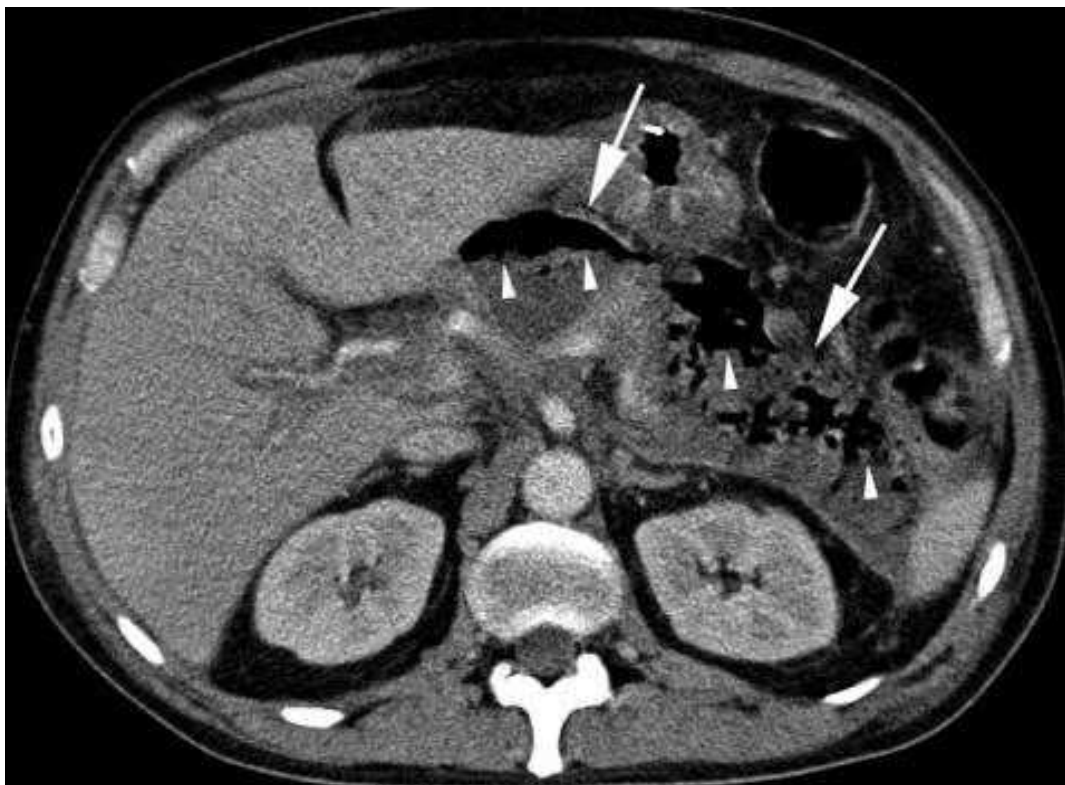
CT image of infected pancreatic necrosis
